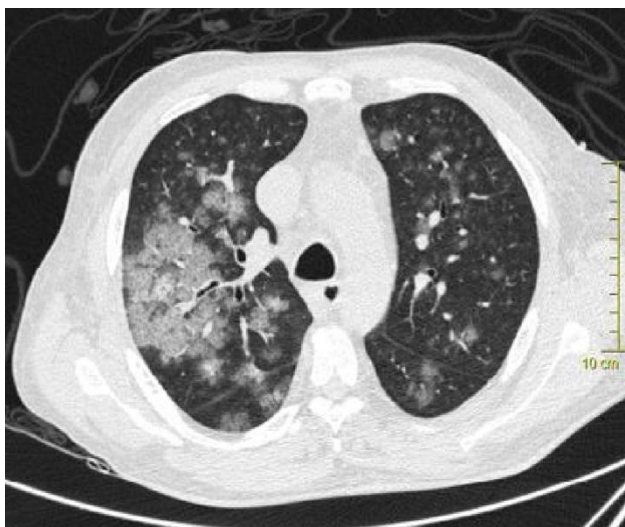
Axial HRCT scan shows areas of ground glass opacity with interlobular septal thickening in bilateral upper lobes.
